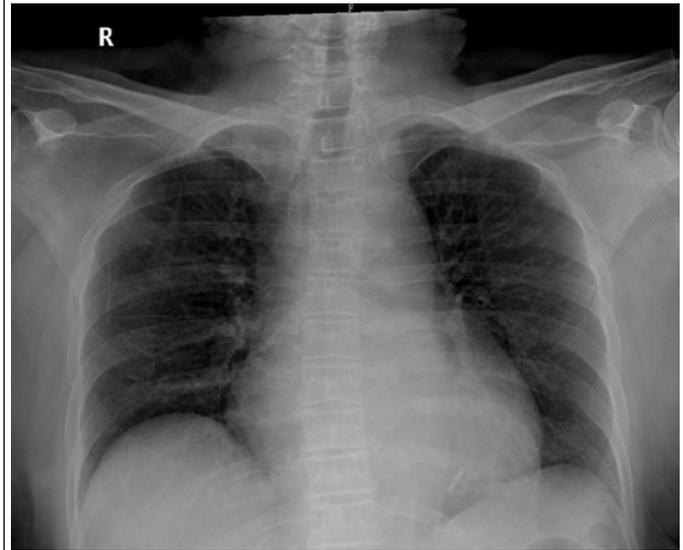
Chest X-ray showing an enlarged cardiac silhouette.
